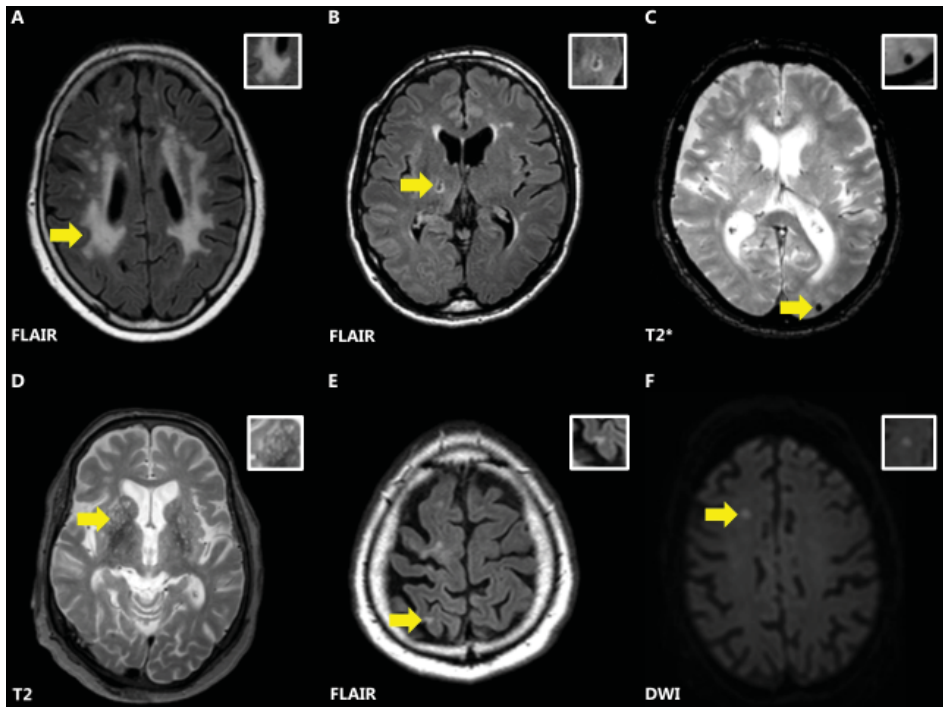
Examples of different SVD lesion types on conventional brain MRI. Depicted with yellow arrows are WMHs (A), a lacune of presumed vascular origin (B), a cerebral microbleed (C), perivascular spaces (D), a cortical microinfarct (E) and a recent small subcortical infarct (F).
